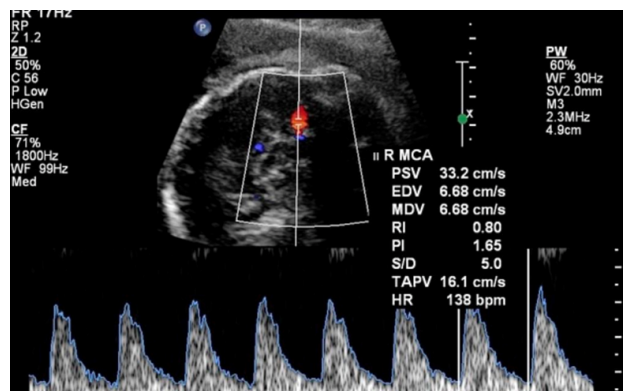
Doppler measuring MCA-PSV value
